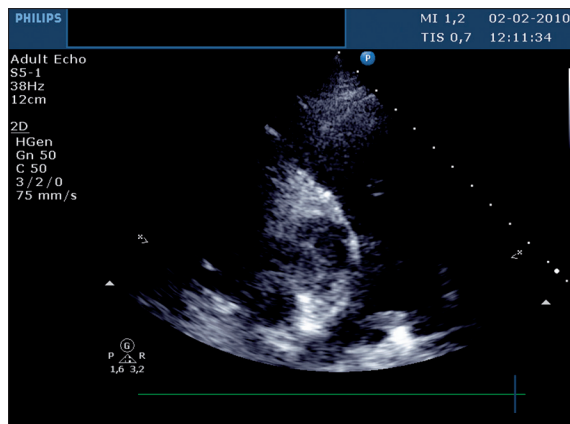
Transthoracic echocardiography showing saddle pulmonary thromboembolus.
